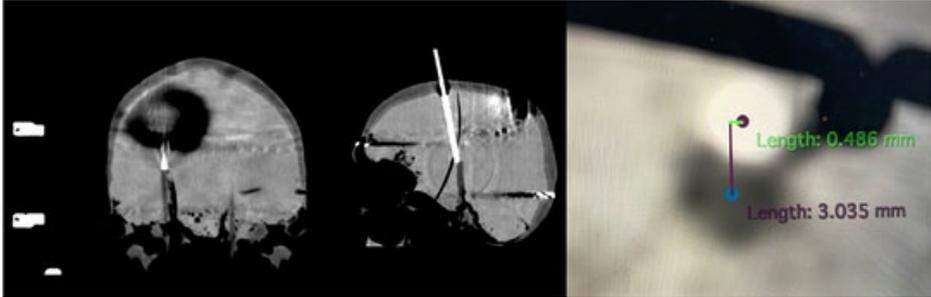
Post-op CT of the 3D-printed skull to assess the accuracy of the procedure.
